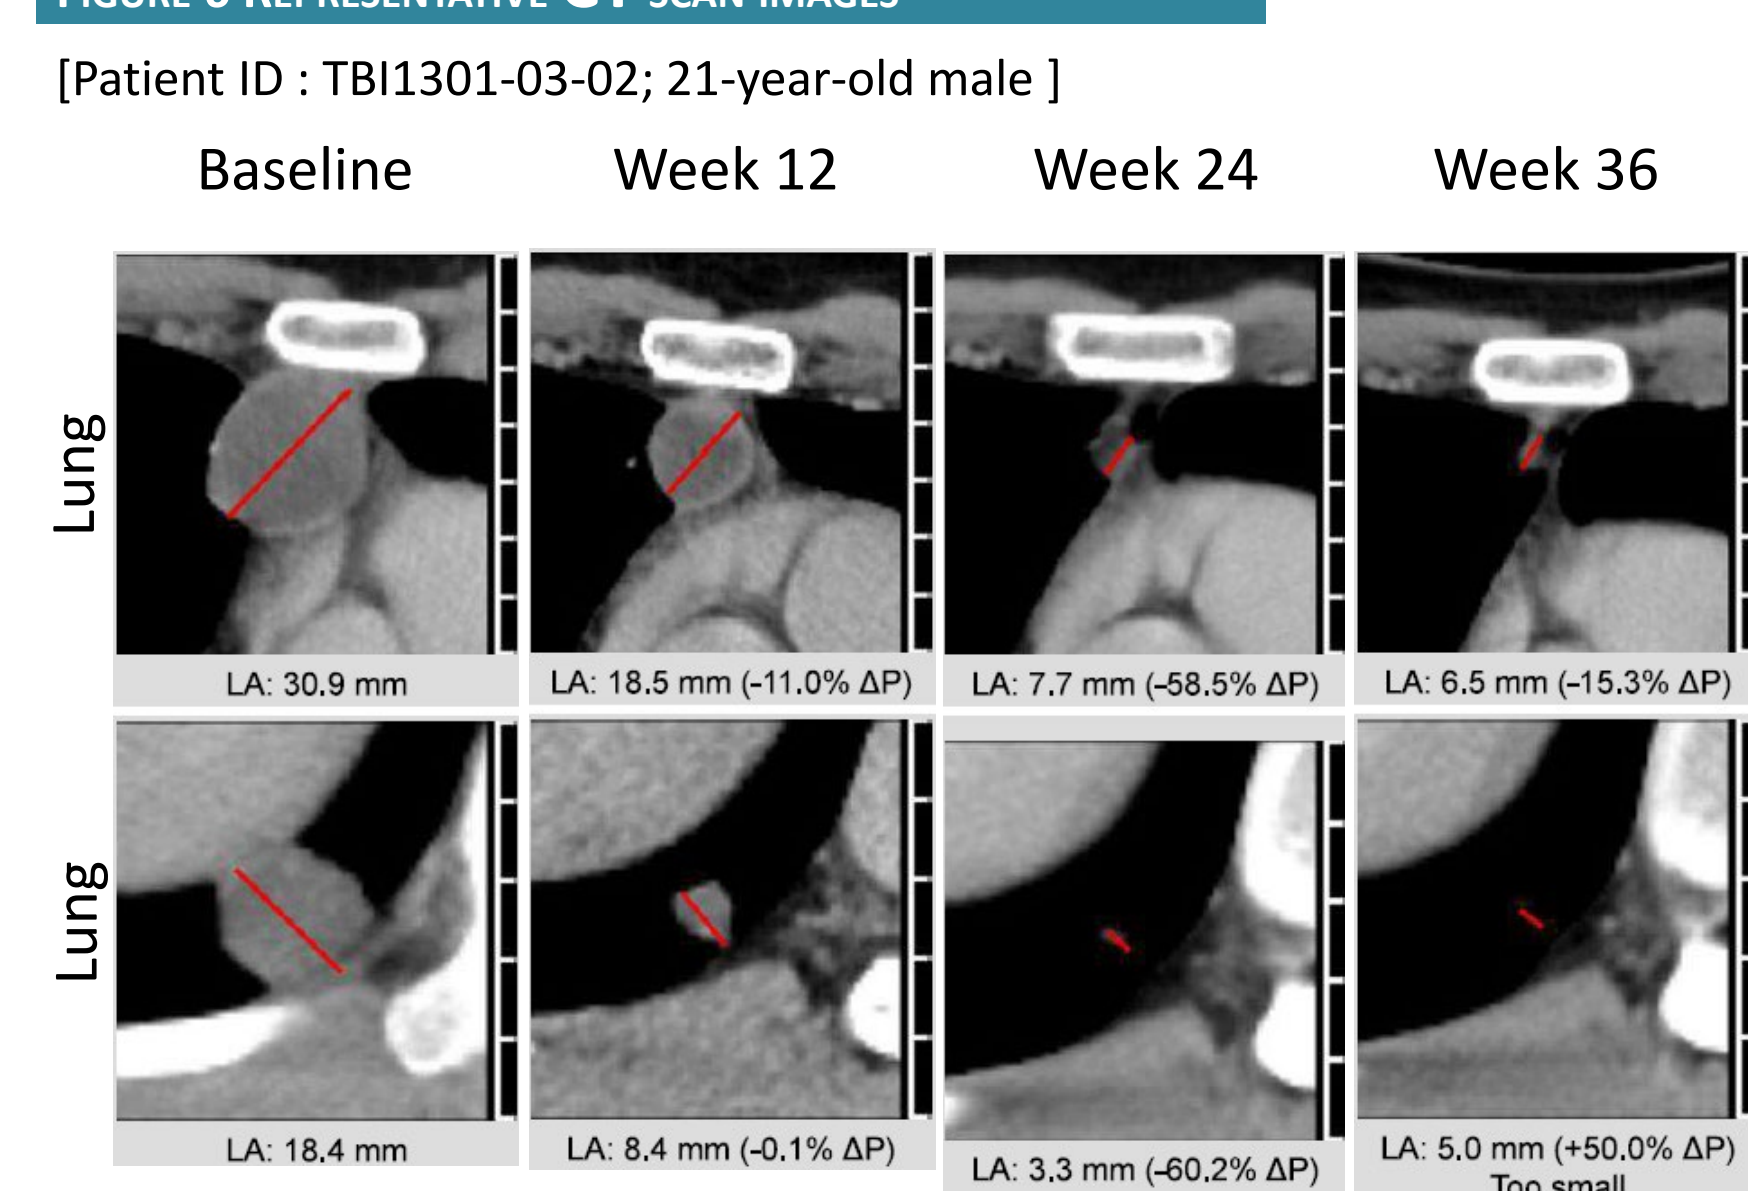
REPRESENTATIVE CT SCAN IMAGES
